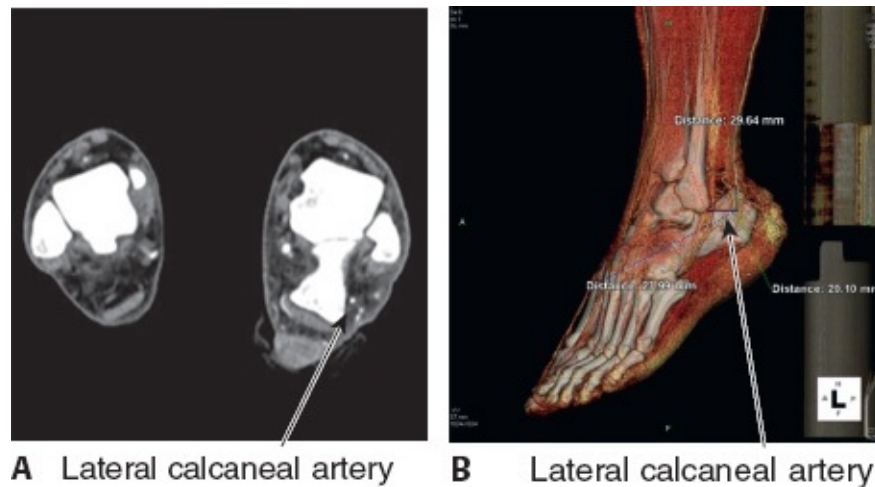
• A,B. CT angiographic image of lateral calcaneal artery.
